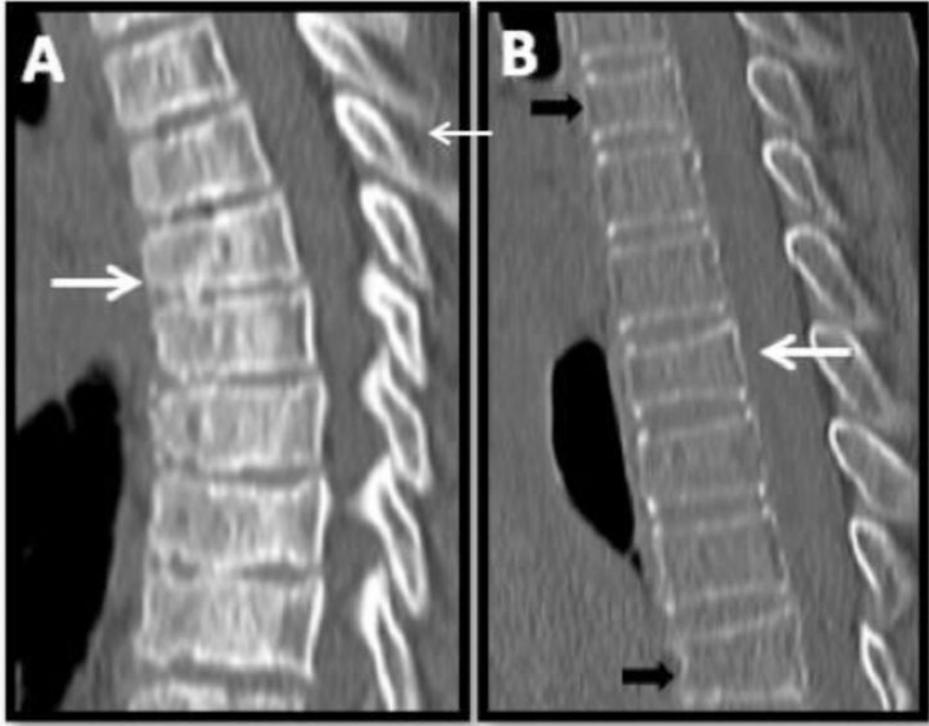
Examples of VCFs (vertebral compression fractures) observed in our patient cohort. (A) CT of the lateral thorax of a 13-year-old female patient shows Genant grade 2 vertebral compression fracture in T7 vertebra (white arrow) with 33% reduction in anterior height. Note the irregularity of the spinal vertebral end plates. (B) CT of the lateral thorax of a 16-year-old male patient shows Genant grade 1 vertebral compression fracture in T8 vertebra (white arrow), with 23% reduction in anterior height. Anterior wedging is also noted in T5 and T11 vertebrae (black arrow heads). Note diffuse osteopenia of the spine.
